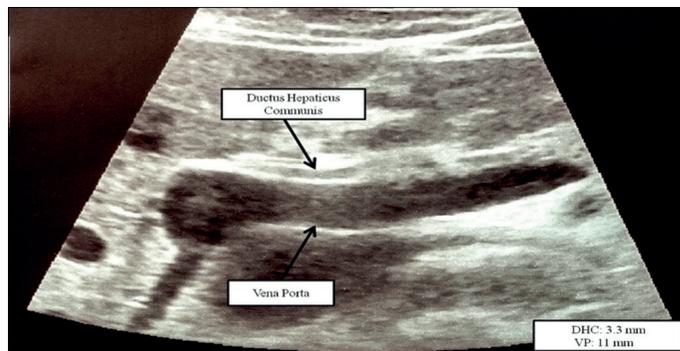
DHC diameter measurement with ultrasonography
